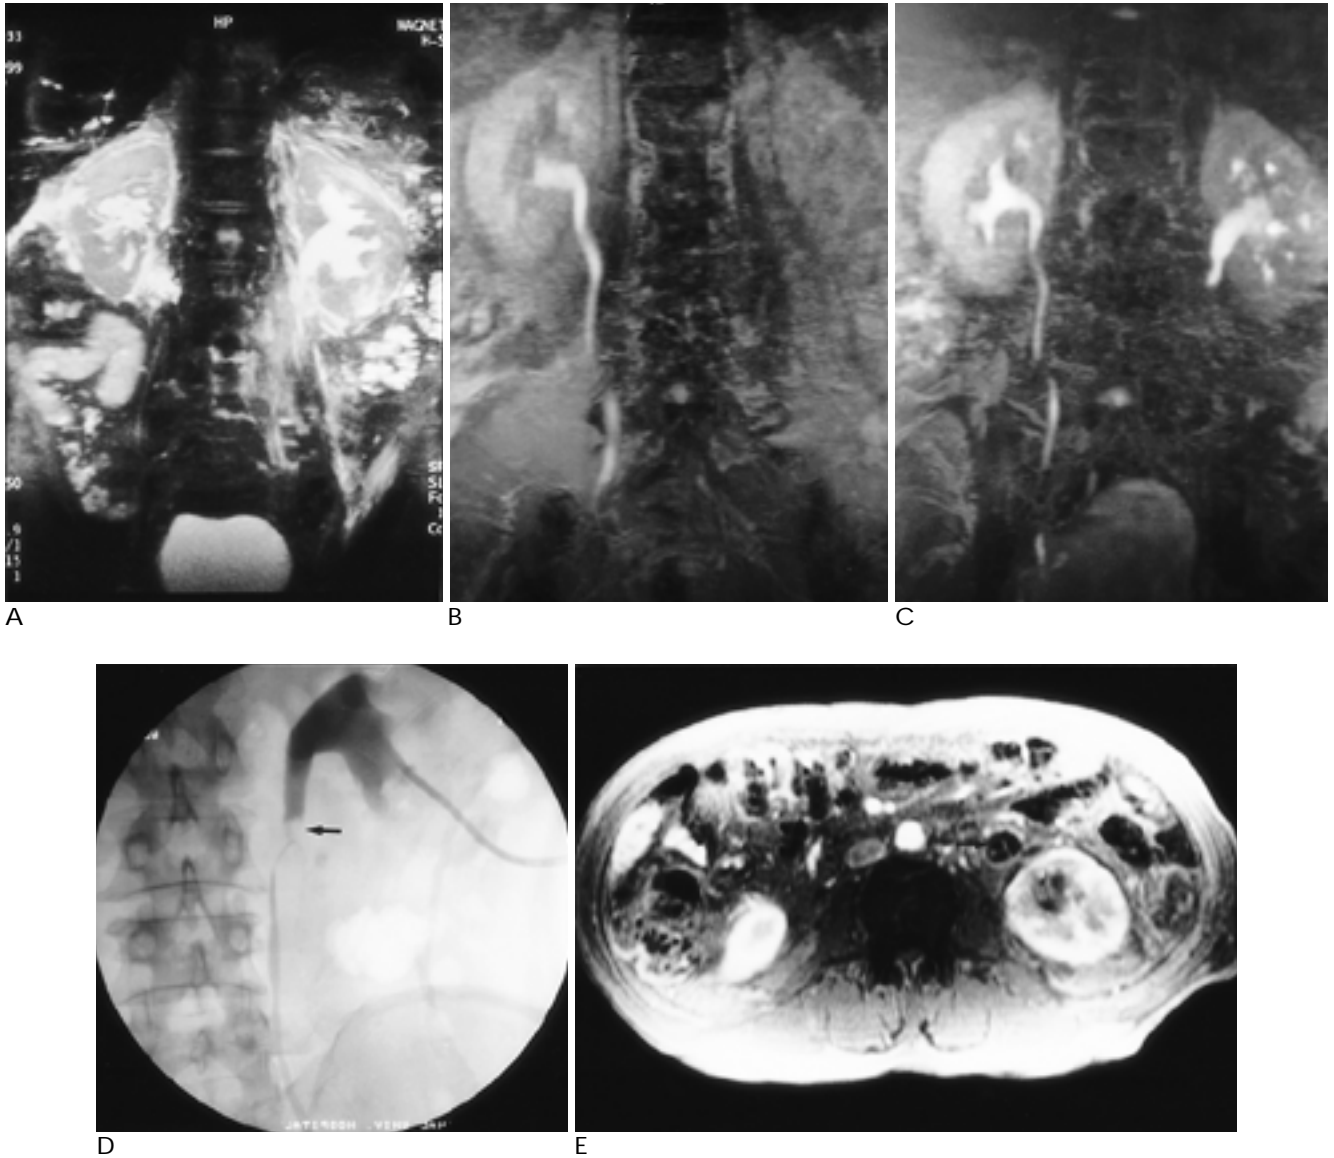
Ureterolithiasis of the left proximal ureter in a 64-old-year man with left flank pain. Ultrasonography revealed left hydronephrosis with no definite stone(not shown). IVU was not performed due to the high level of serum creatinine (5.6 mg/ml). A. MIP image from fat-suppressed, coronal HASTE shows dilatated pelvocaliceal system of the left kidney with no definite filling defect due to superimposed small bowel loops. B. MIP image from diuretic-enhanced excretory MR urography (15/4, 50 °flip angle) performed in 10 minutes after furosemide and gadopentetate dimeglumine injection shows non-visualization of the left kidney. C. MIP image from diuretic-enhanced excretory MR urography (30/4, 50 °flip angle) performed in 30 minutes after furosemide and gadopentetate dimeglumine injection shows complete obstruction of the left proximal ureter. D. After percutaneous nephrostomy of the left kidney, nephrostogram shows a filling defect due to a stone (arrow) in the proximal ureter with incomplete obstruction. E. Axial enhanced T1-weighted gradient echo(TR 93msec, TE 4.1/1msec) MR image demonstrates a non-enhancing small hypointense stone (arrow) in the left proximal ureter.
